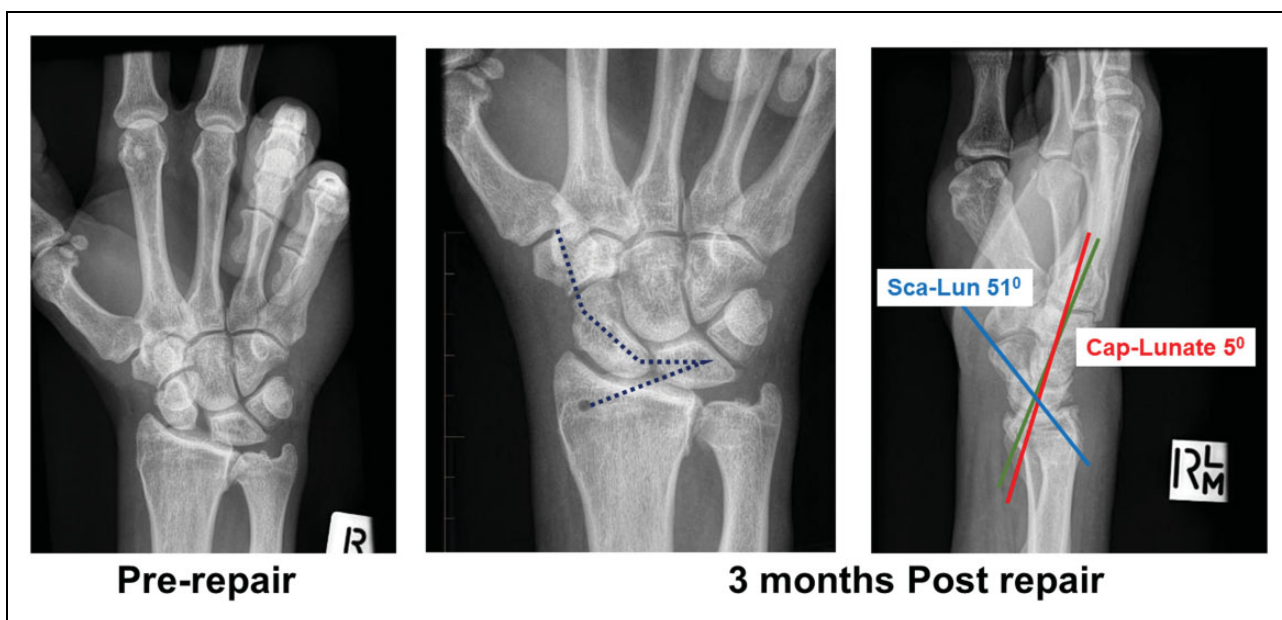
Pre- and postoperative radiographs showing carpal realignment. Sca-Lun: scapholunate angle; Cap-Lunate: capitolunate angle.
